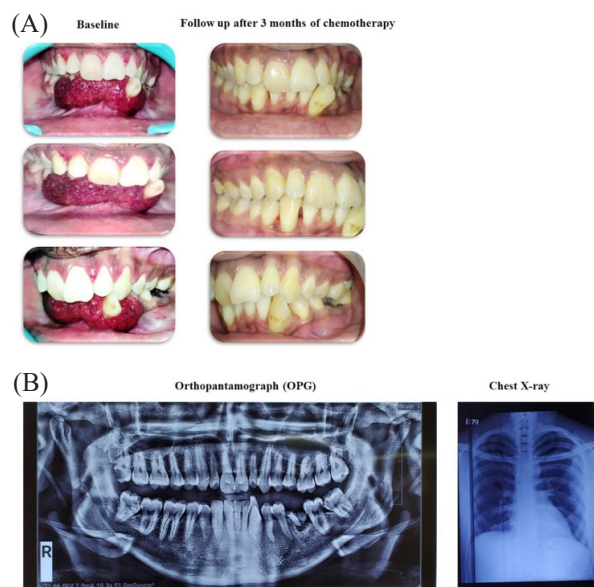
(A) Clinical photographs at baseline and 6-month follow up; (B) Orthopantomograph (OPG) and chest x-ray showing no abnormalities.
